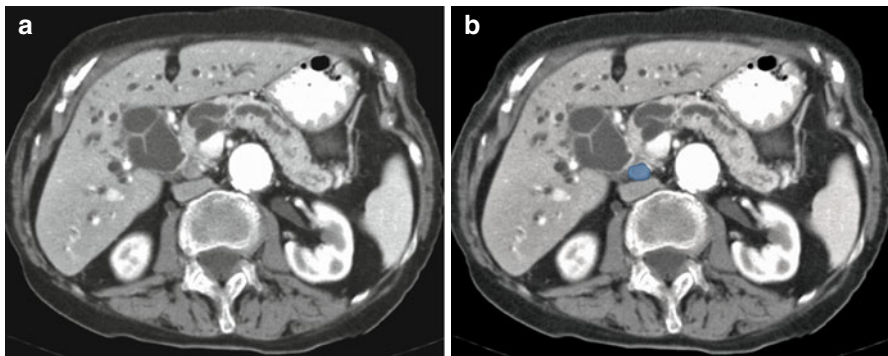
(a, b) Axial CT image in a patient with primary pancreatic adenocarcinoma shows metastatic retropancreatic lymph node (*blue*)
